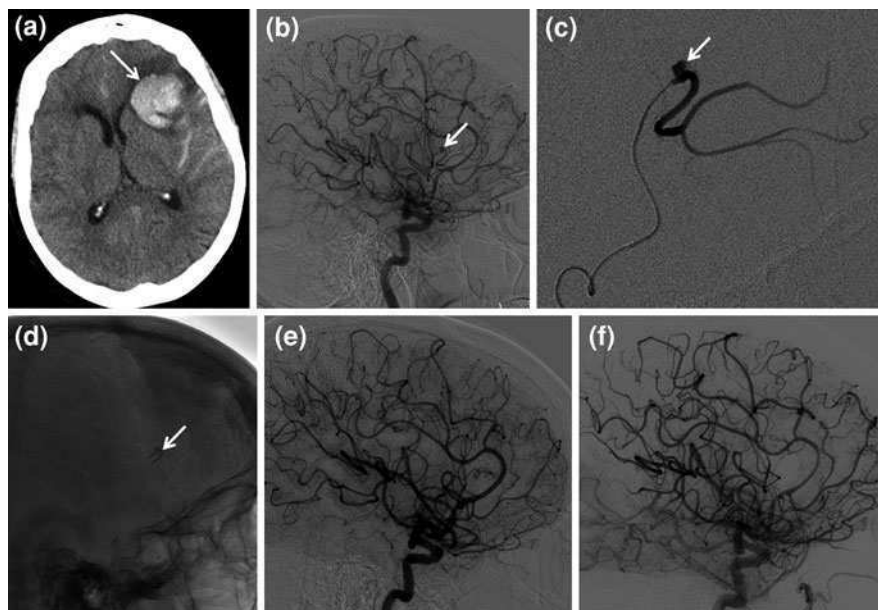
A 62 year-old female presented with speech difficulty and right-sided weakness. A non-contrast head CT (a) reveals a large left fronto-temporal hematoma and acute subarachnoid hemorrhage (arrow). DSA (arrow in b, lateral) and selective microcatheterization and angiography c demonstrates a small mycotic aneurysm arising from the frontal branch of the anterior division of the left middle cerebral artery. A liquid embolic agent (n-butyl-2-cyanoacrylate) was injected through the microcatheter (glue cast shown in d, arrow) thereby occluding the aneurysm (DSA, e Follow-up angiography at 6-months f shows complete obliteration of the aneurysm and the recruitment of leptomeningeal anastomoses to the territory of the occluded branch
